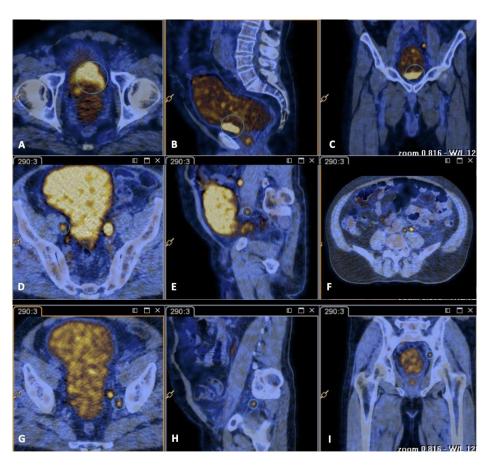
FDG-PET/CT showing significant metabolic activity in bilateral pelvic lymph nodes and mild metabolic activity in the femoral and retroperitoneal LN. (A) Transverse low-pelvic slice showing significant metabolic activity in the anterior aspect of the bladder (circled in green). (B) Sagittal pelvic slice showing significant metabolic activity in the anterior aspect of the bladder (circled in green). (C) Coronal anterior pelvic slice showing significant metabolic activity in the anterior aspect of the bladder (circled in green). (C) Coronal anterior pelvic slice showing significant metabolic activity in the anterior aspect of the bladder (circled in green). (D) Transverse high-pelvic slice showing significant metabolic activity in the right pelvic lymph nodes (circled in green). (E) Right parasagittal slice showing significant metabolic activity in the right pelvic lymph nodes (circled in green). (F) Mid-abdominal slice showing mild metabolic activity in retroperitoneal lymph nodes (circled in green). (G) Transverse mid-pelvic slice showing significant metabolic activity in the left pelvic lymph nodes (circled in green). (H) Left parasagittal slice showing significant metabolic activity in the left pelvic lymph nodes (circled in green). (I) Coronal posterior pelvic slice showing significant metabolic activity in the left pelvic lymph nodes (circled in green). (I) Coronal posterior pelvic slice showing significant metabolic activity in the left pelvic lymph nodes (circled in green).
